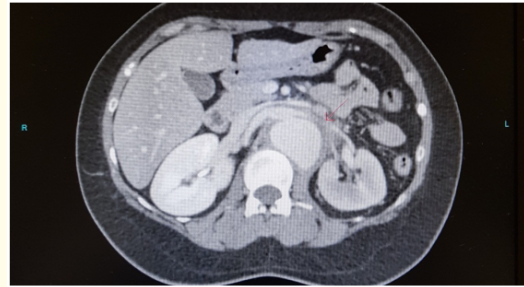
CT angiography of the whole abdomen.
